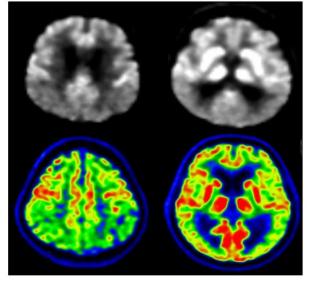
<sup>18</sup>F FDG-PET showing increased uptake of bilateral basal ganglia and thalami.
